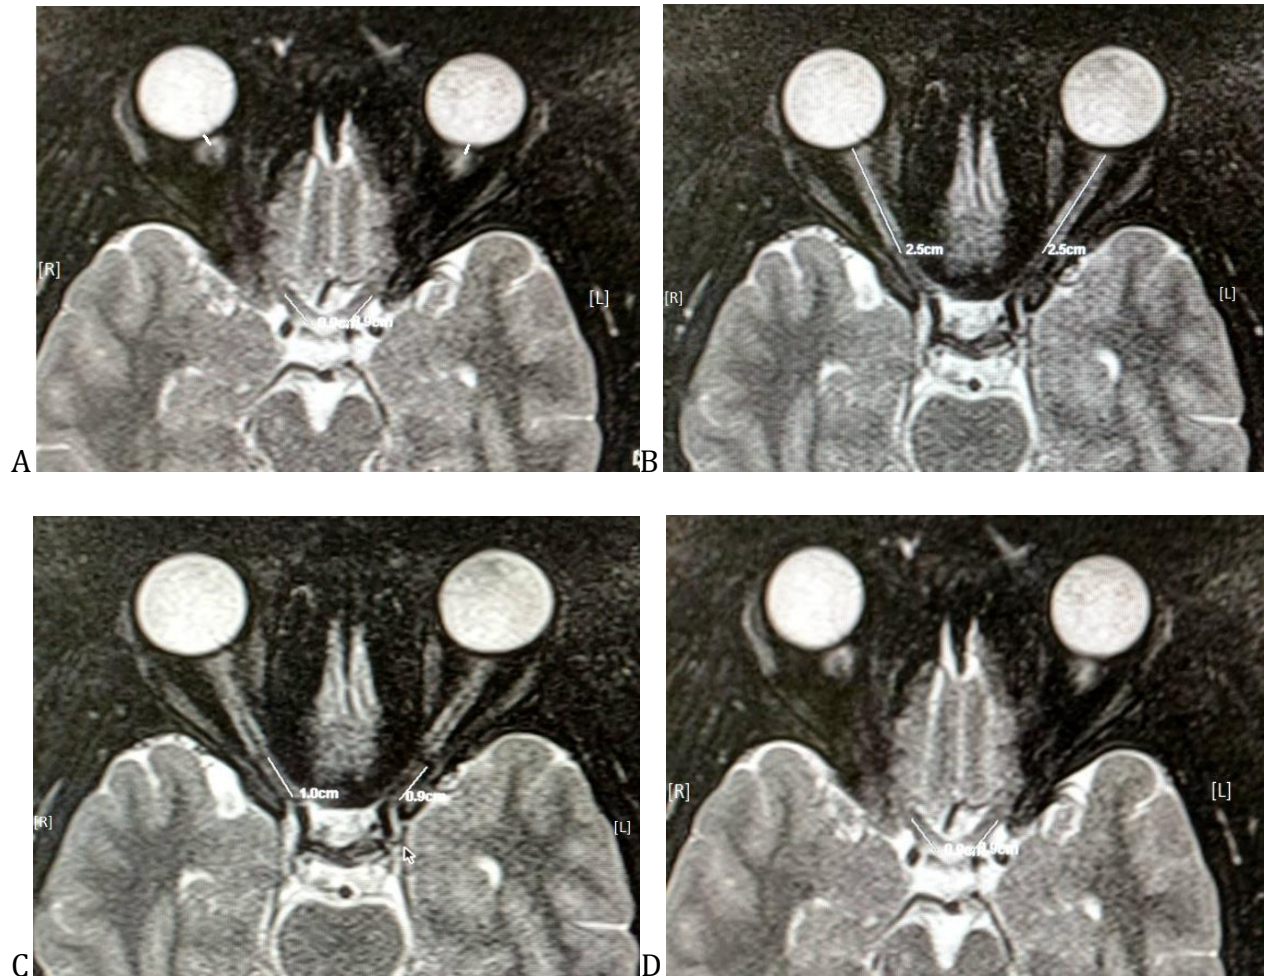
Example of our measurement method, axial T2-weighted FSE image demonstrates bilateral presentation of the ON sheath in a 19-year-old female and the patient had no diabetic, or hypertension or any eyes problems A. the area of the ocular part B. the area of orbital part C. area of canalicular part D. area of the intracranial part
